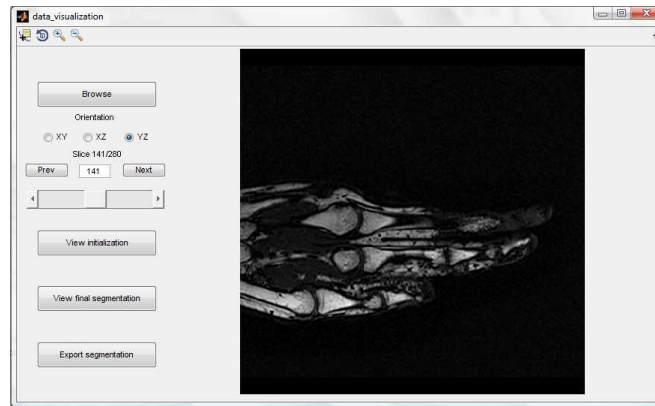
Grafical User Interface (GUI) for visualization of the MRI slices, the initial 2D contours and the final segmented bone regions
